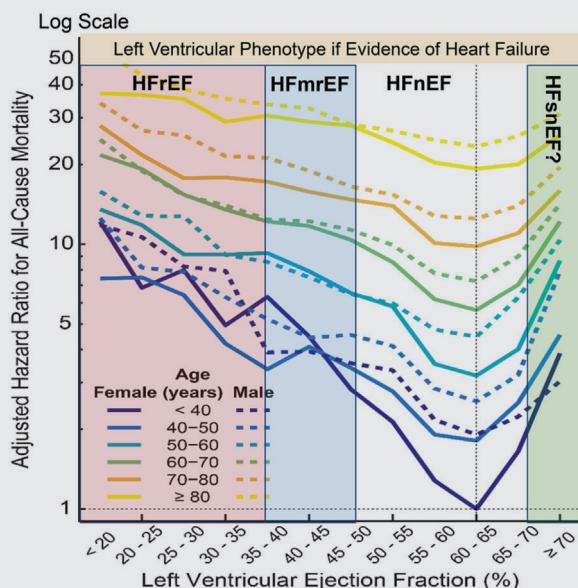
All-cause mortality according to left ventricular ejection fraction reported on >350 000 routine echocardiograms stratified by age and sex.
